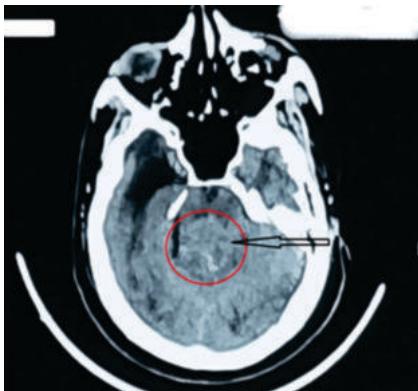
CT of the Brain (Axial Plane) Showing Fourth Ventricular Ependymoma.
